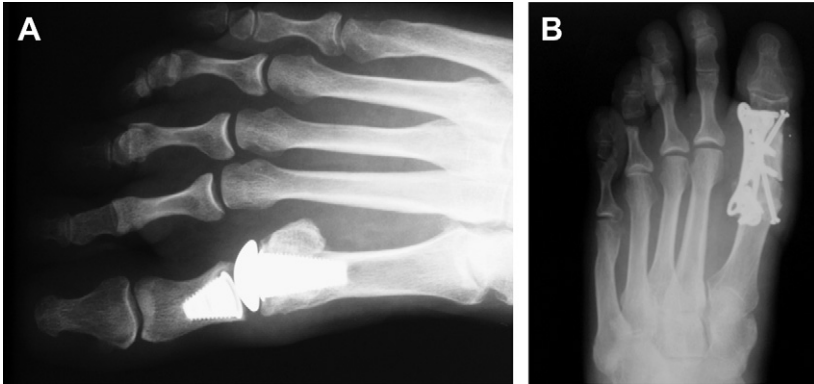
(A) Anteroposterior radiograph of a patient with failed first MTP joint arthroplasty caused by implant malposition. (B) A bone block fusion was performed as salvage procedure.
